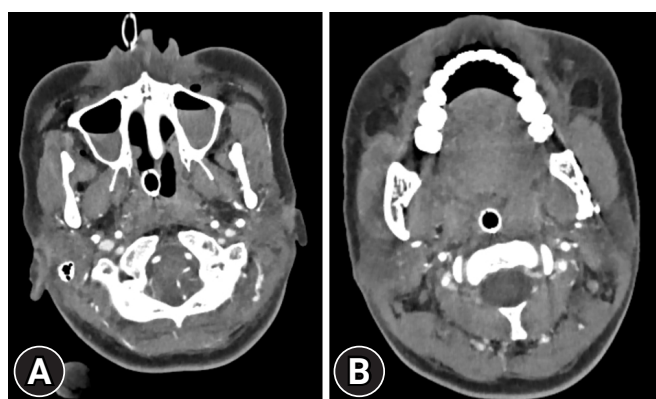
Computed tomographic angiography of the neck revealed no significant active bleeding but did show hemorrhagic fluid in the bilateral maxillary sinuses, along with hematoma in (A) the oral cavity (B) and naso-oropharynx.
